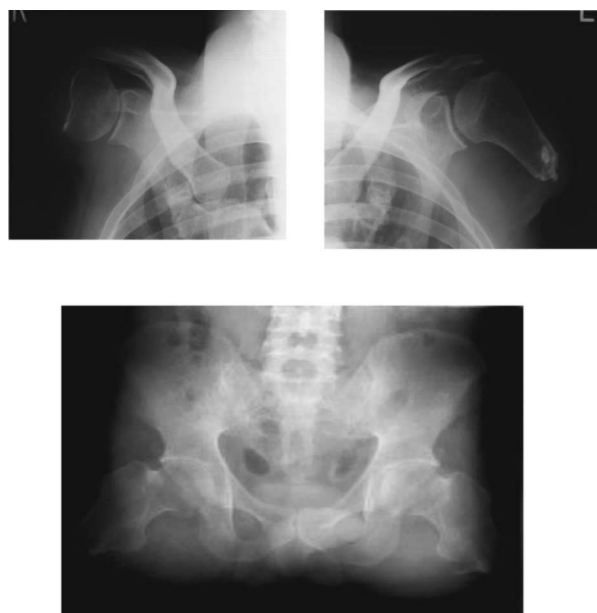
X-ray film of 4 limb stumps.
